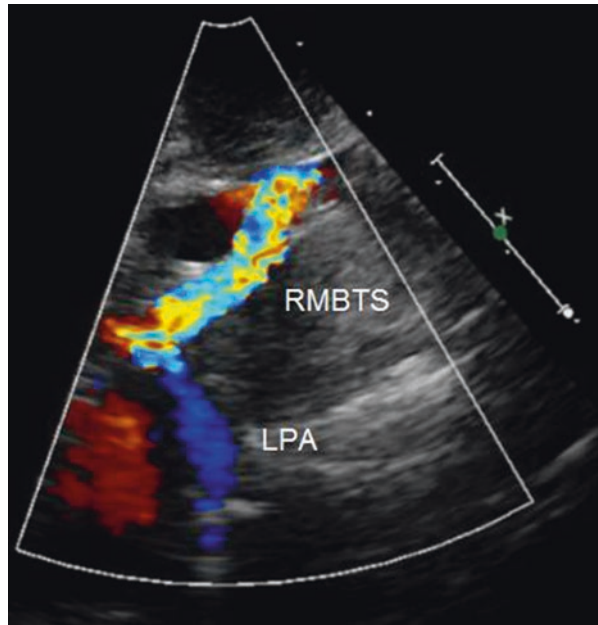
Echocardiogram with color flow mapping demonstrating a right modified Blalock-Taussig Shunt (RMBTS) demonstrated with color flow mapping. LPA left pulmonary artery
